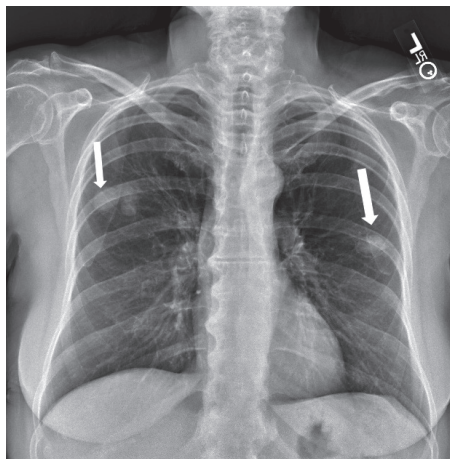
Chest X-ray showing bilateral upper lobe pulmonary nodules (arrows).
